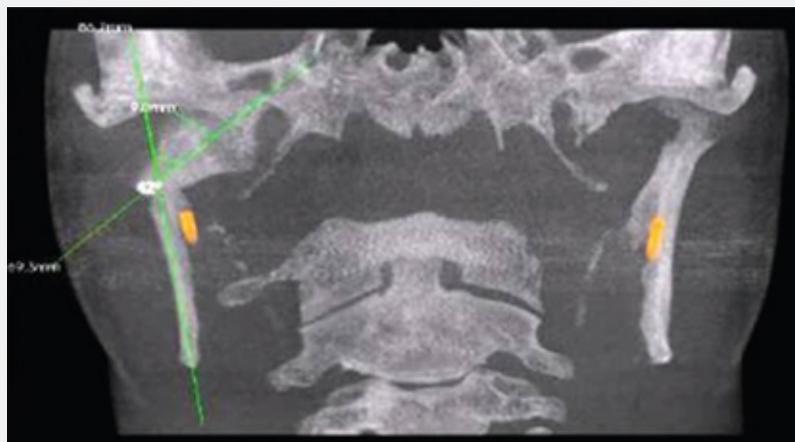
Measurement of degree of displacement of condyle using cone-beam computed tomography.
